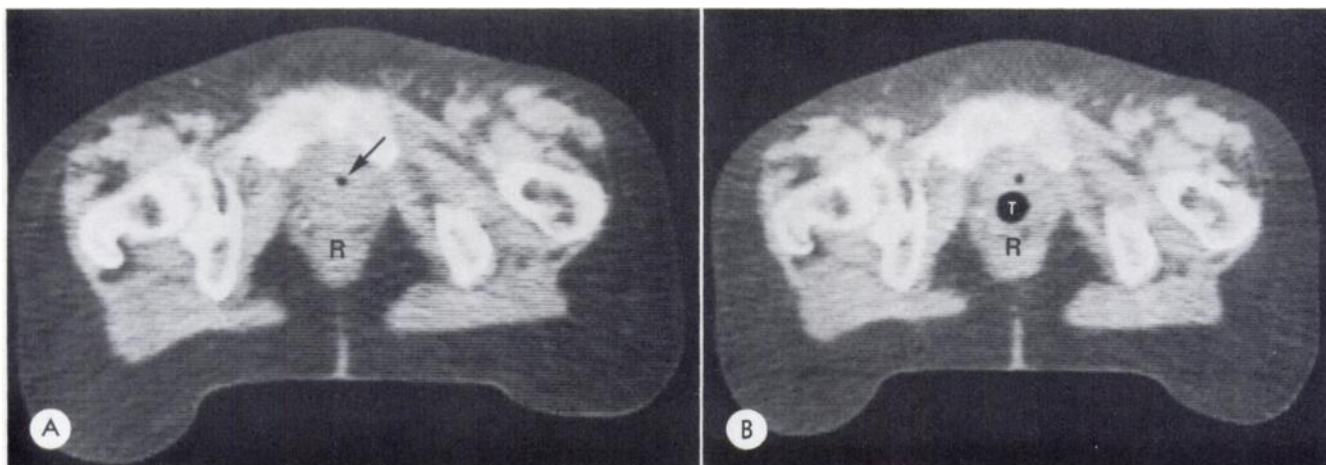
A, CT scan of normal female pelvis at level of symphysis pubis showing collapsed vagina indistinguishable from distal rectum (R) and region of bladder neck, which is identified by gas-containing lumen of catheter (arrow). B, CT scan of same patient at same level after tampon insertion showing tampon gas shadow (T) distending and identifying vagina. Distal rectum (R) again identified.
